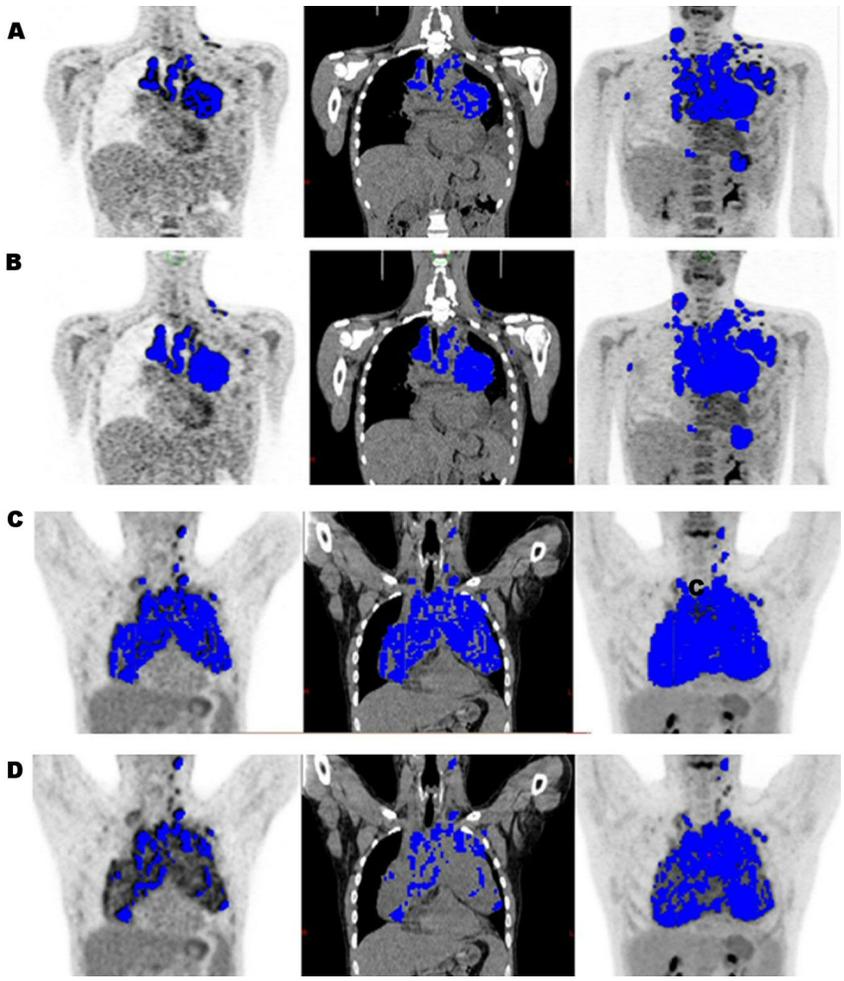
Representative coronal images of PET (left) CT (middle) and MIP images (right) are shown for two patients. Visible tumour is underestimated in one patient using a percentage threshold (A) compared to an absolute threshold (B). In another patient visible tumour is adequately assessed using a percentage threshold (C) but underestimated using an absolute threshold (D). The same absolute threshold (SUV of 4) and percentage threshold (41% of maximum SUV) were used for both patients.
